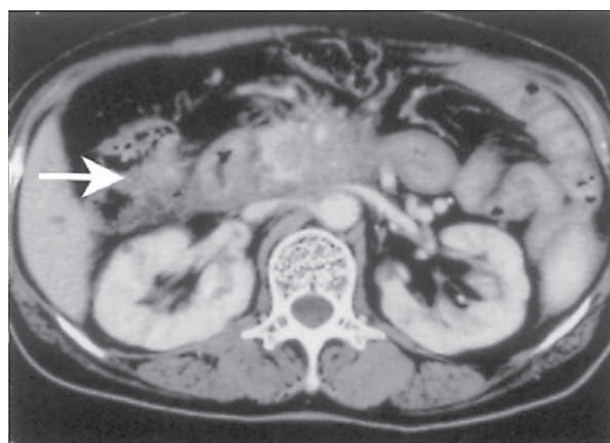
Coronal (A) and axial (B) FDG-PET, CT (C, D) and MR (E) scans of a 76-year-old male with pancreatic cancer (Patient no. 6 from Table 1). Focal, intense uptake of FDG was found in the pancreatic head portion (*arrow* in A). Small, focal uptake of FDG was found in the liver (*arrowhead* in A, *white arrow* in B). CT image shows the mass shadow at the pancreatic head (C). CT image missed the liver metastasis (D). Postcontrast MR image shows a small metastasis (*white arrowhead*) at the S8 segment of the liver (E).
